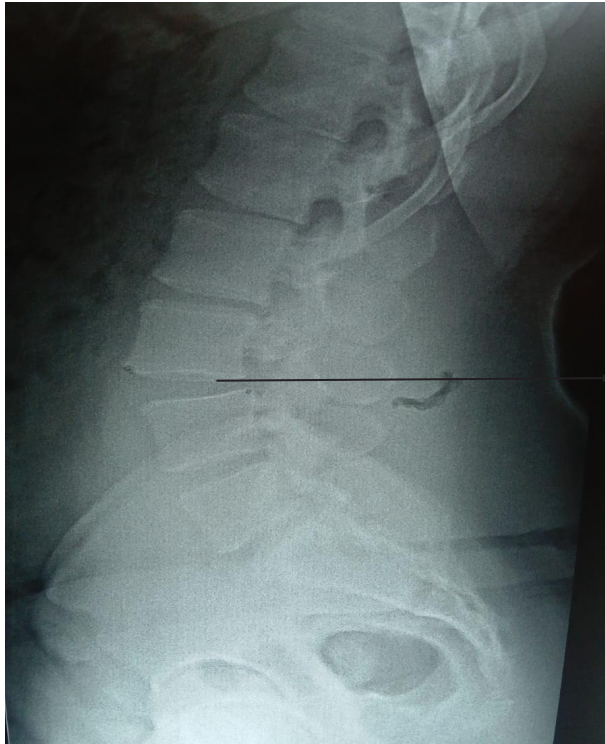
Lateral lumbar spine radiograph showing bilateral L3 spondylolysis with anterolisthesis
